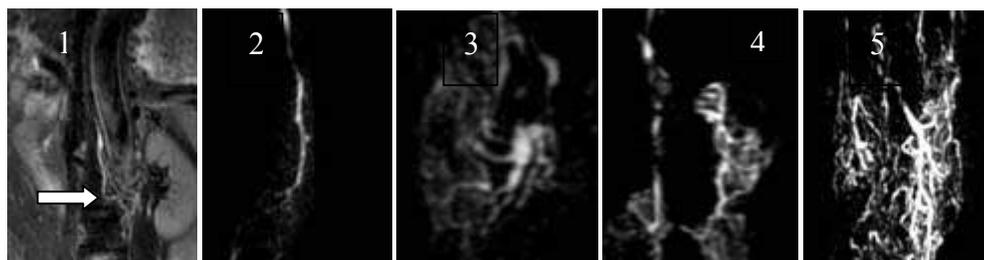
The cisterna chyli (long white arrow) is tubular hyperintense signal on coronal fat-suppressed T2-weighted image, and 2 lymph trunks drain into it.
